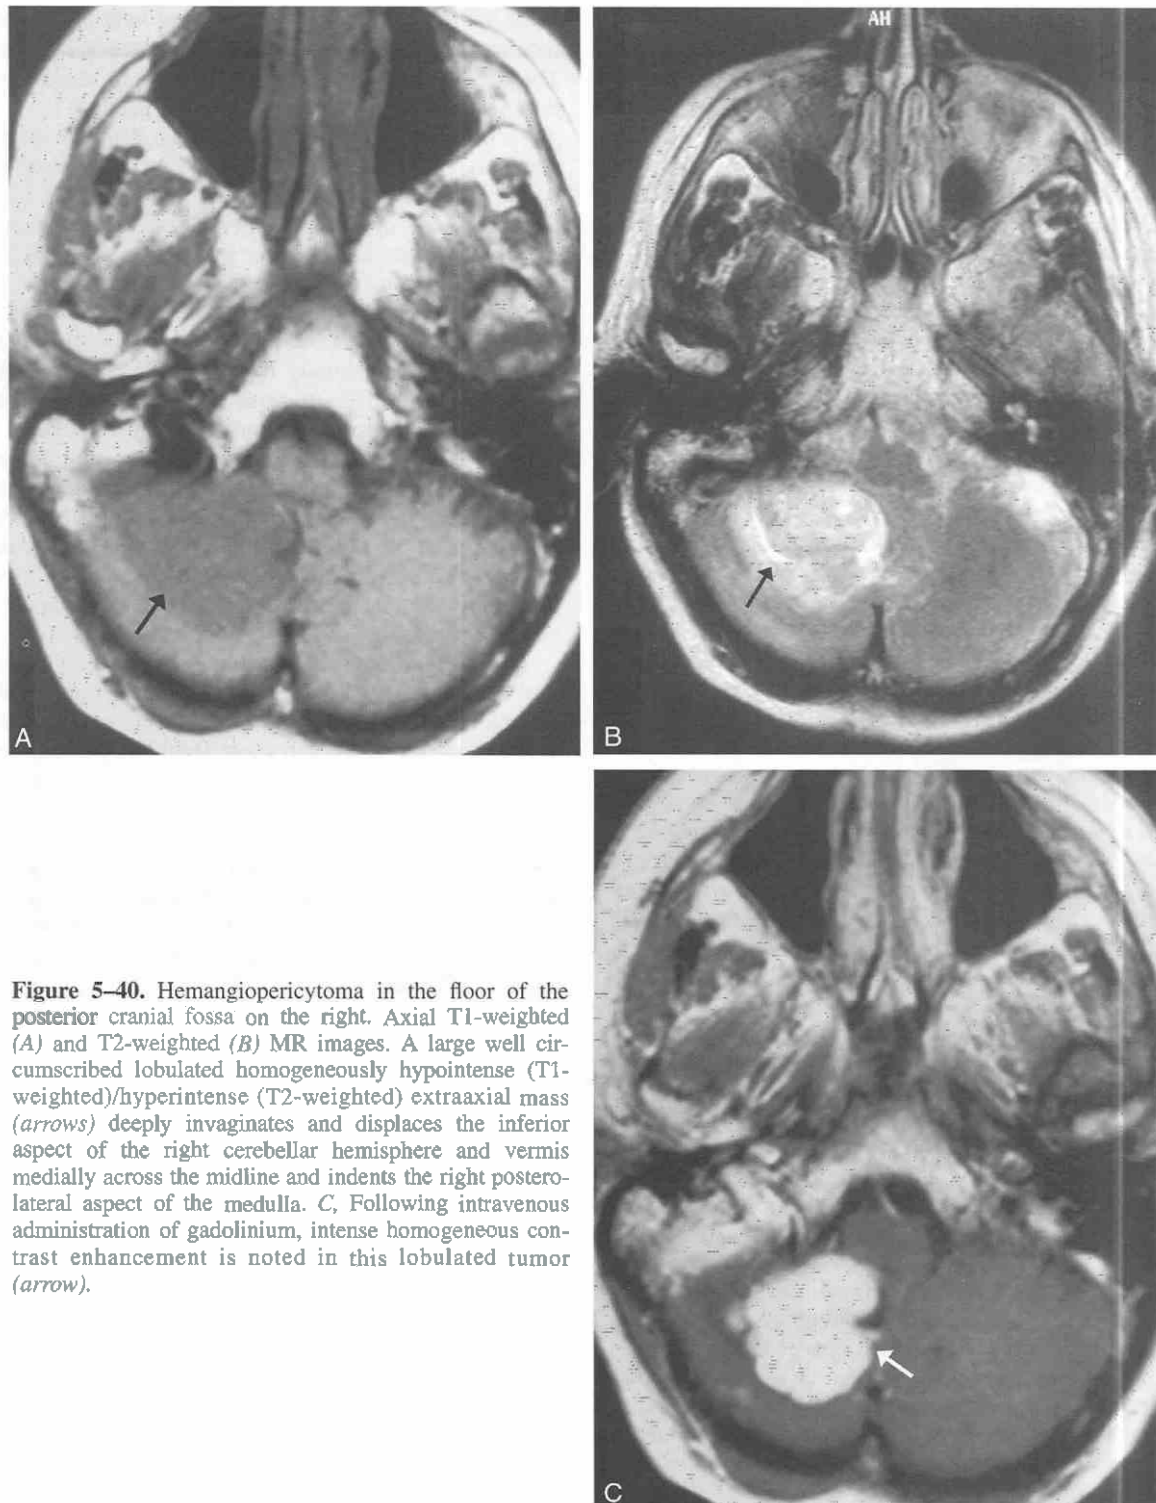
Hemangiopericytoma in the floor of the posterior cranial fossa on the right. Axial T1-weighted (A) and T2-weighted (B) MR images. A large well circumscribed lobulated homogeneously hypointense (T1-weighted)/hyperintense (T2-weighted) extraaxial mass (arrows) deeply invaginates and displaces the inferior aspect of the right cerebellar hemisphere and vermis medially across the midline and indents the right posterolateral aspect of the medulla. C, Following intravenous administration of gadolinium, intense homogeneous contrast enhancement is noted in this lobulated tumor (arrow).
